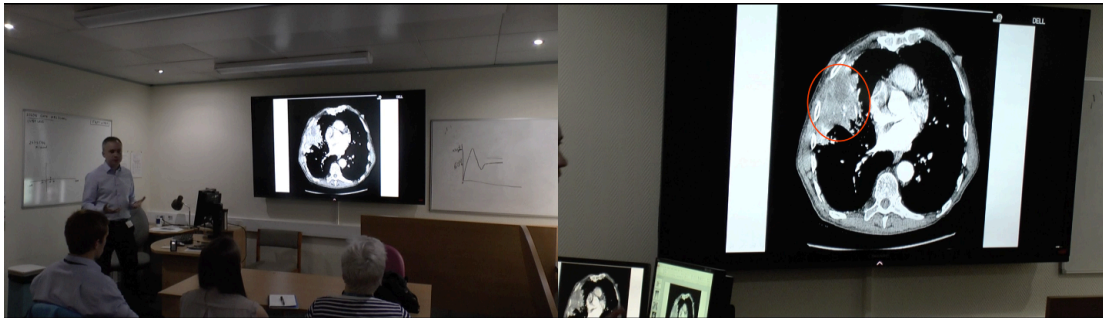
CT used as part of case 4: '40 male cough'. Dr. Maxwell transitions forward to the next slide which displays the patient's CT image. I have highlighted the 'wedge shaped area' he uses to describe the appearance of infection.
